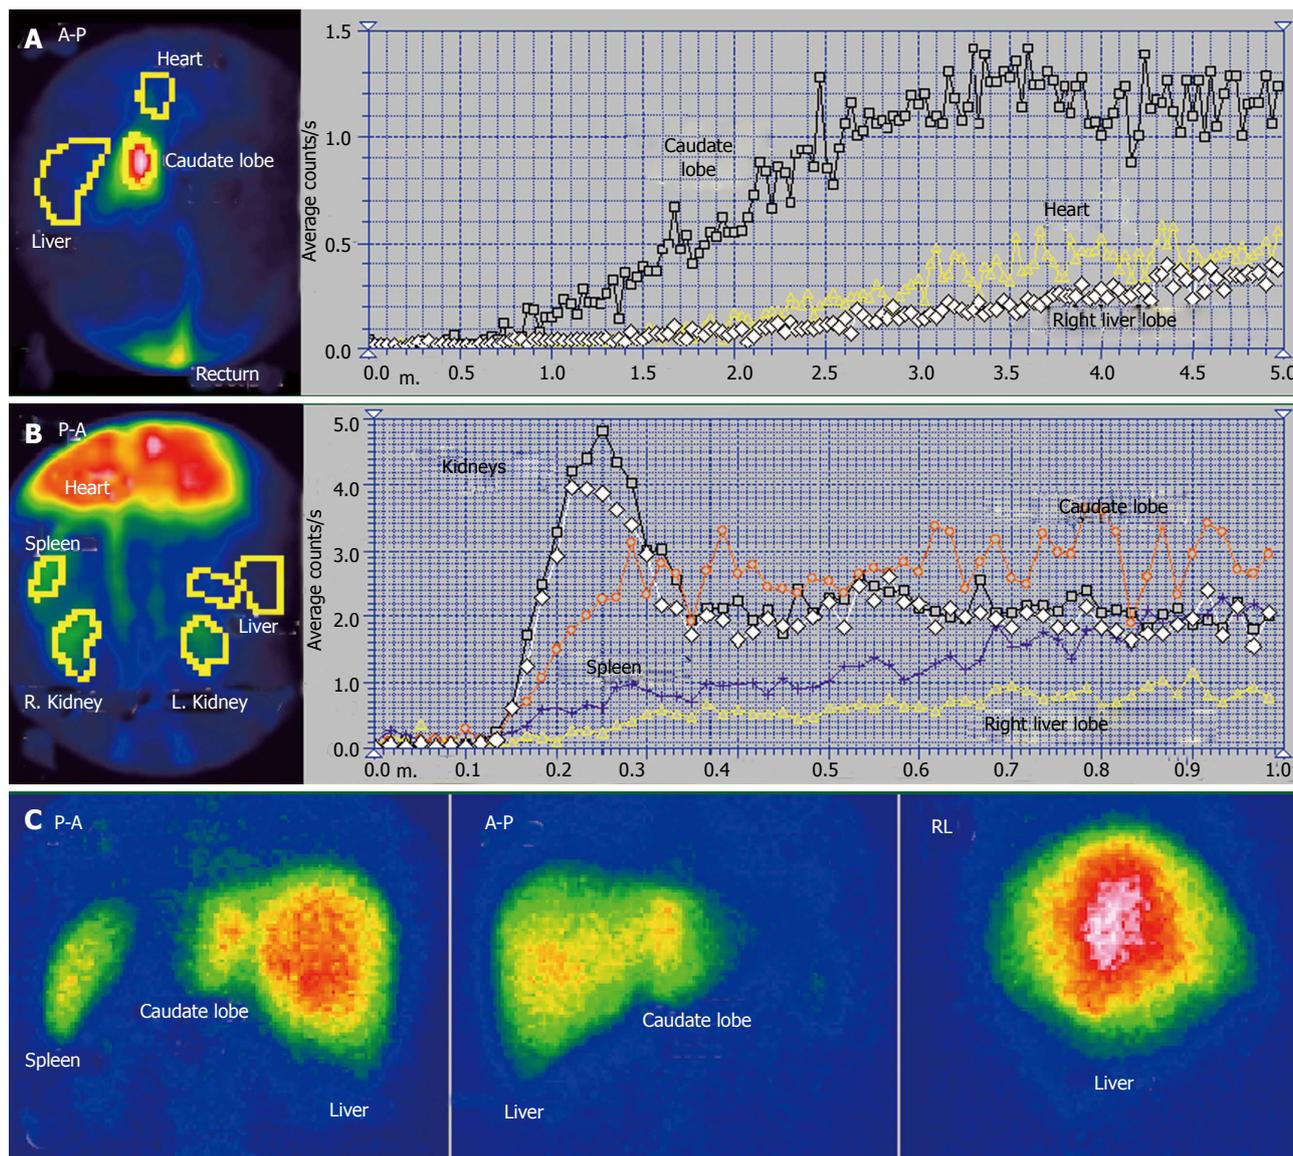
Budd-Chiari syndrome with old obstruction of the left hepatic vein and recent obstruction of the middle and right hepatic veins. A: Per-rectal portal scintigraphy; B: Liver angioscintigraphy; C: Liver scan.
